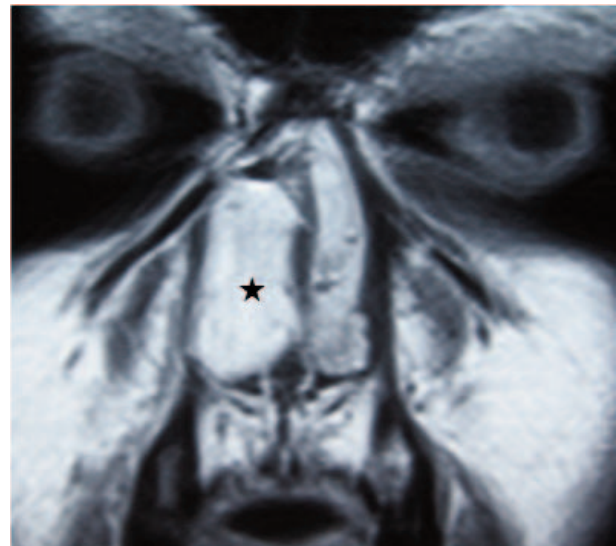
MRI, axial SE T2. Hyperintense lesion arising from the nasal septum is seen in the right nasal cavity.
